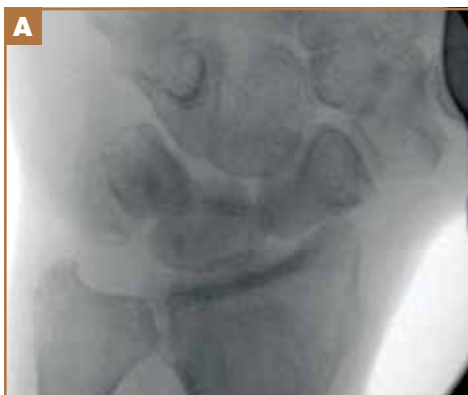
Intraoperative fluoroscopic image (A) taken through the triangle, compared with standard intraoperative plain radiograph (B) taken in the same position.
